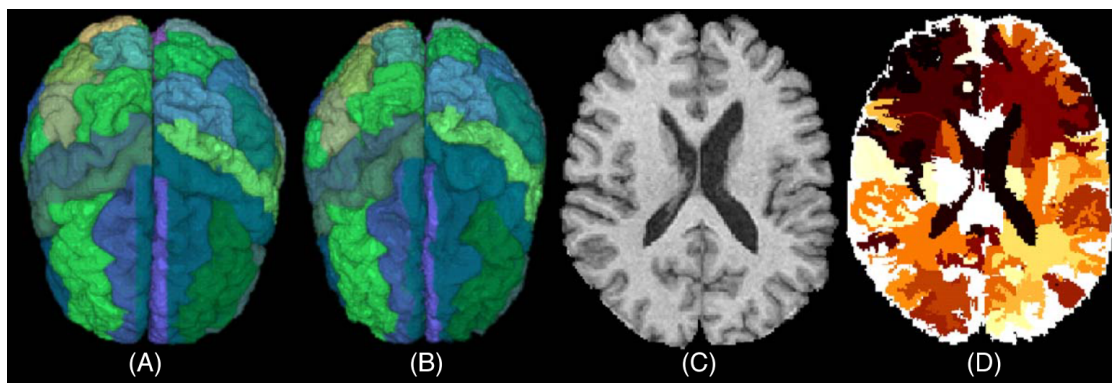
Example of brain atlas used by Lao et al. [72]. (A) Parcellated brain image used as an atlas for the definition of ROIs. (B) Another individual's image parcellated via a high-dimensional elastic warping of the atlas on the left, using the HAMMER method. (C–D) One cross-section of the individual's original MR image and the corresponding labeled (segmented) image. Source: Lao et al. [72]
